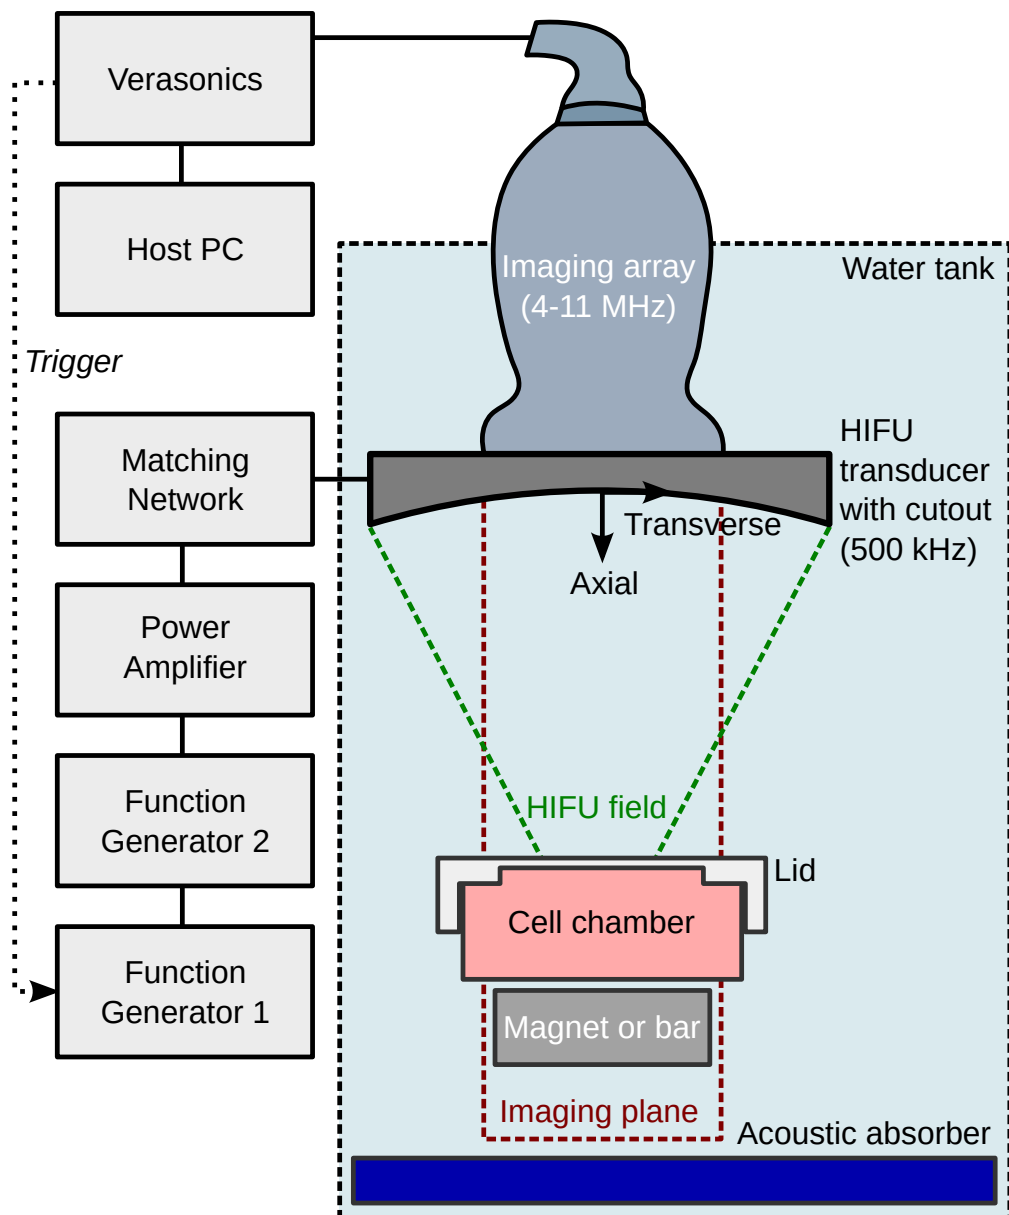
Setup for *in vitro* cell transfection experiments (not to scale). A cross-sectional view through the water tank is shown. Samples were placed in a cell chamber at the focus of a 500 kHz HIFU transducer with a rectangular cutout for an imaging array. Two function generators were used to allow treatment to take place at a multiple of the imaging frame rate. In preliminary experiments cells were contained in an OptiCell™ chamber instead of the dish/lid system and the Verasonics ultrasound platform was substituted with the Zonare-based system described in Chapter 3.
